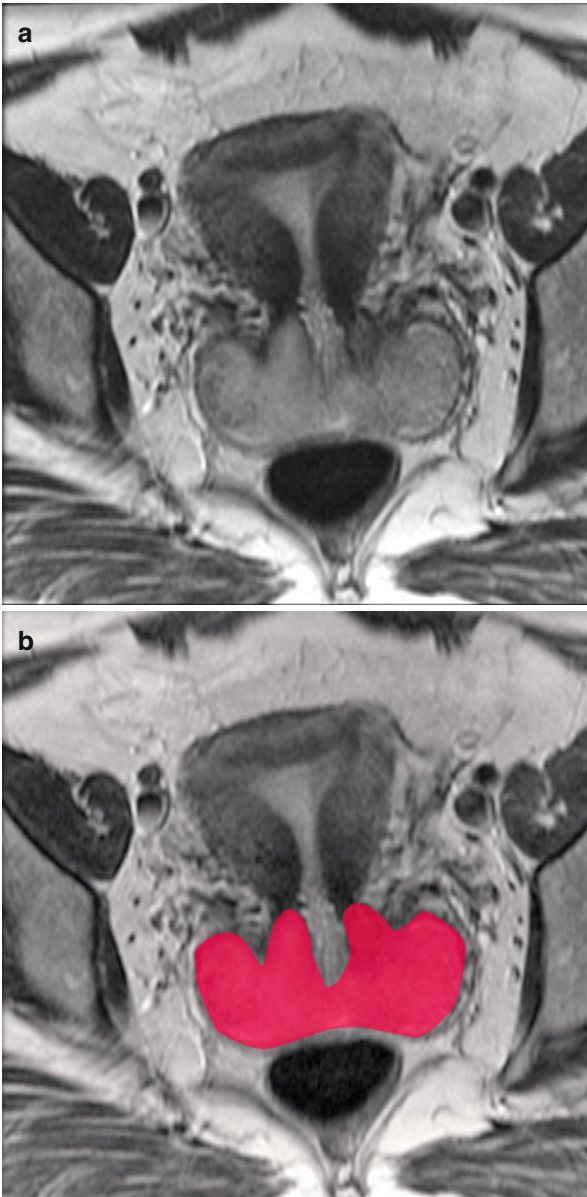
(a–d) Axial T2-weighted MR image shows the cervical cancer (*red*). Axial contrast-enhanced CT image in the same patient (c, d) shows the enlarged metastatic left external iliac lymph node (*orange*)
